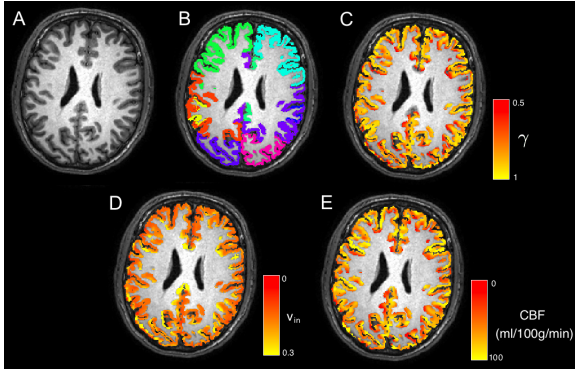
Example control data. A) T1-weighted slice, B) lobe parcellation, C) cortical CBF D) cortical v_{in} E) cortical orientation dispersion γ .
